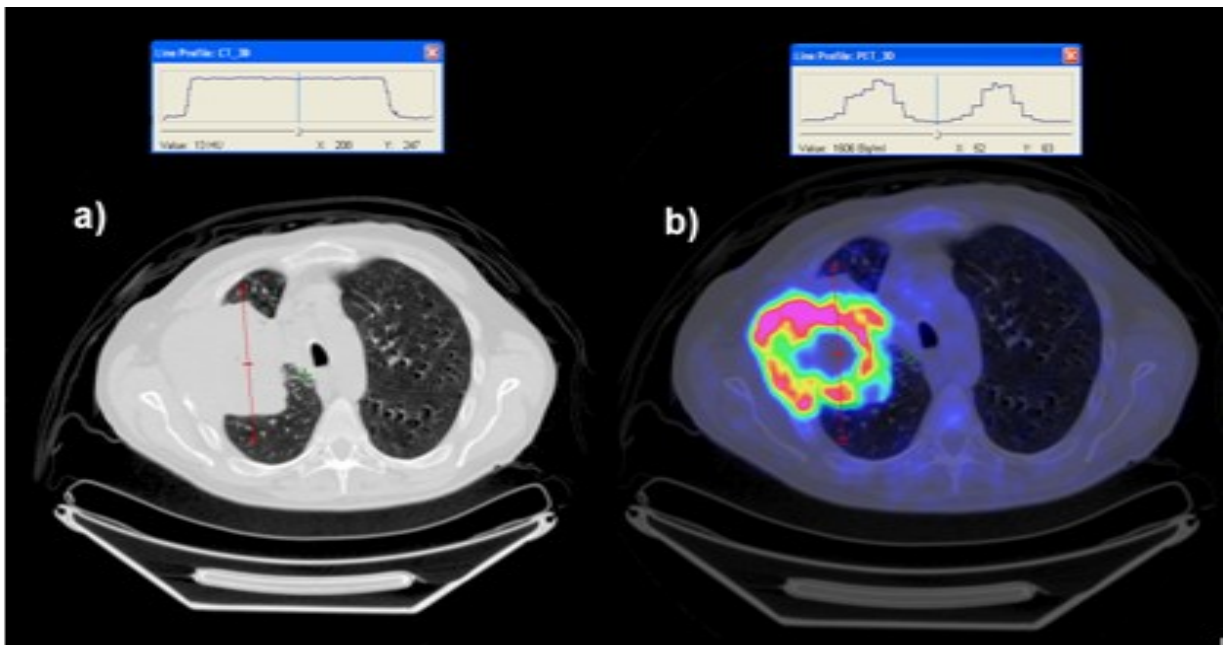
A comparison of CT (a) and PET (b) for a large lung tumour. Image adapted from Devic et al.⁵⁰
